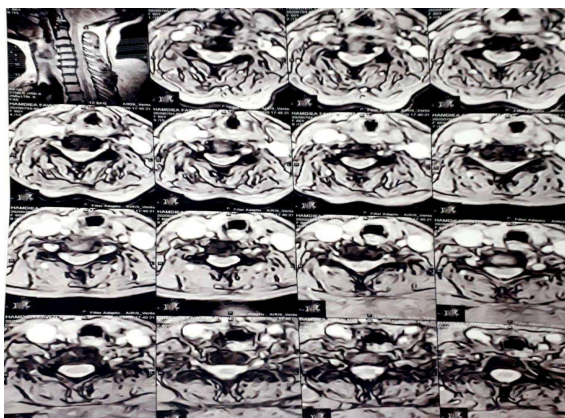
Case 1 Preoperative T2 MRI transverse view of cervical vertebrae.
